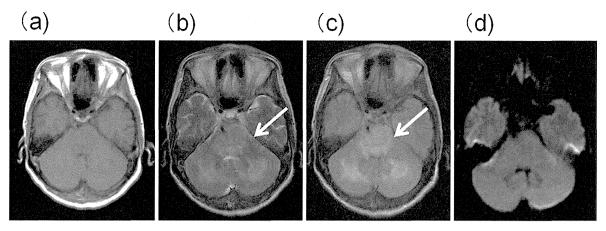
MRI findings of the brain stem and cerebellum opon admission. (a) T1WI. (b, c) T2WI and FLAIR. High intensity signals (arrow) were observed. (d) DWI.
